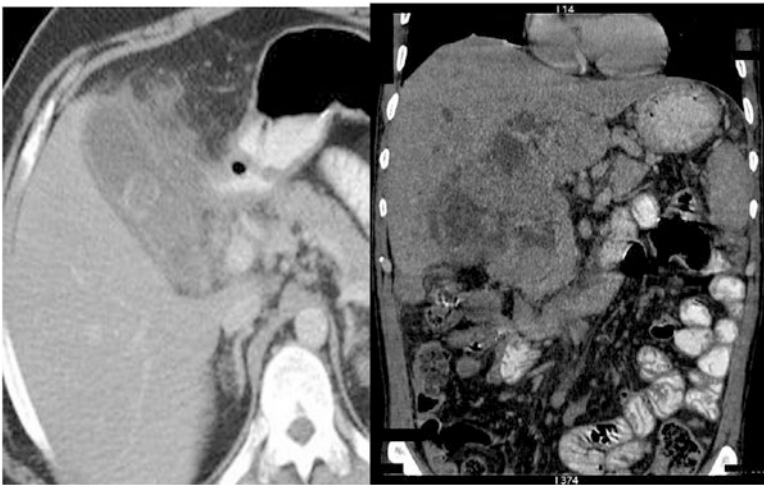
CT scan of the abdomen showing features of cholecystitis
